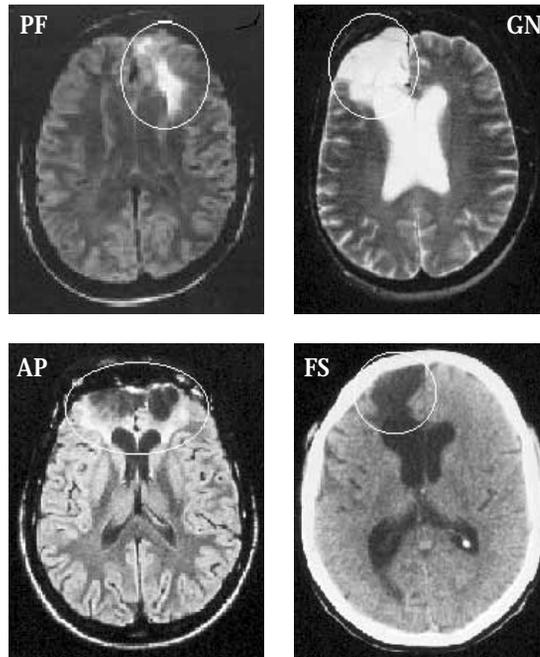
MRI/CT brain scans of four neurological patients with rostral prefrontal damage. All patients achieved superior scores on IQ tests, and all achieved excellent scores on traditional executive tasks such as the Wisconsin Card Sorting and Verbal Fluency tests. However they all showed significant behavioral organization problems in everyday life. (PF: Goel Grafman, 2000; GN: Goldstein et al. 1993; AP and FS: Shallice & Burgess, 1991. Site of rostral lesions are circled. The lesions are different colors because of their differing pathologies and the different methods used to image them. Some scans have been left-right transposed from the originals for ease of understanding, for example, left hemisphere is on the left of figure etc.)
